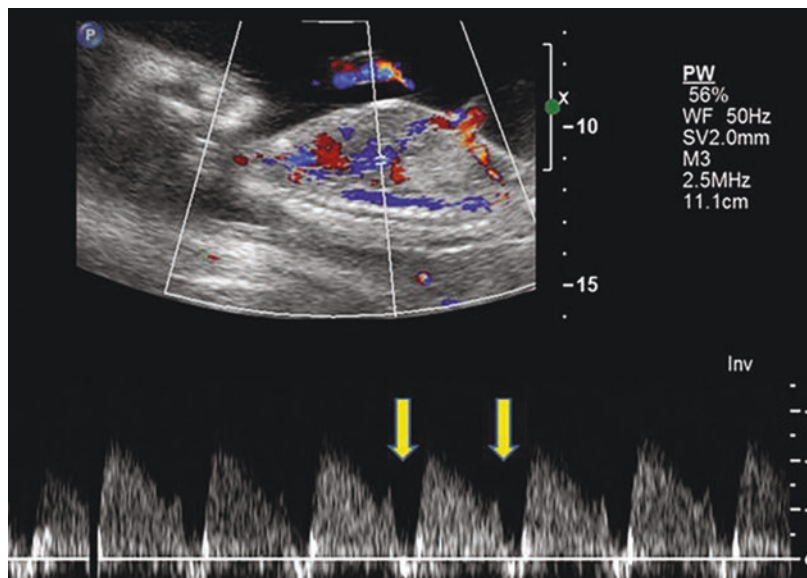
Ductus venosus Doppler velocimetry in TTTS. Reversed a-wave is evident (arrow). This is a sign of cardiac failure in the recipient
